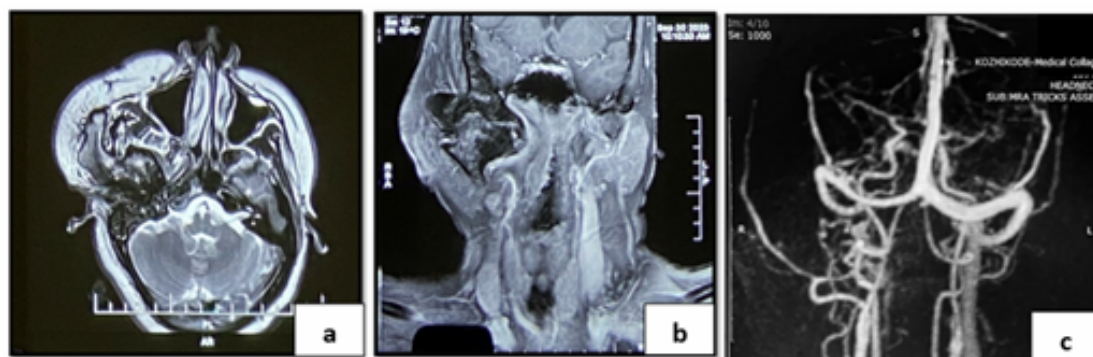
MRI: Figure 4a and 4b: Lipomatous enlargement of soft tissues on the right side of face extending from temporal bone below to level of mandibular ramus involving temporalis muscle, masseter muscle, pterygoid muscles, and muscles of facial expression, right hemi tongue, with gross enlargement of right mandible condyle with degeneration. Figure 4c: MRI angiography showing splaying of internal maxillary and superficial temporal artery in relation to right TMJ region.
